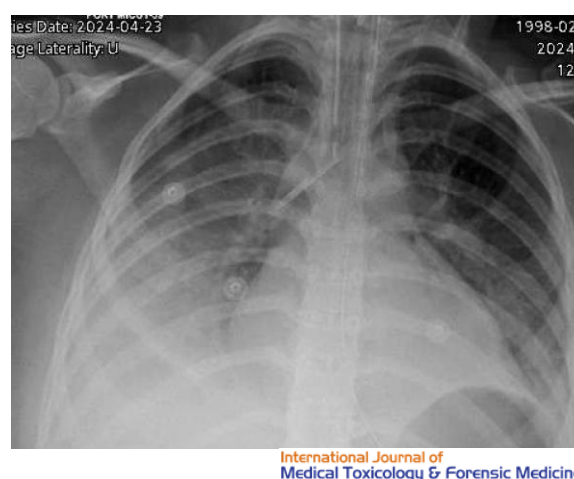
Post-intubation chest X-ray showing right pulmonary infiltrates suggestive of aspiration pneumonia and bilateral pleural effusions.
